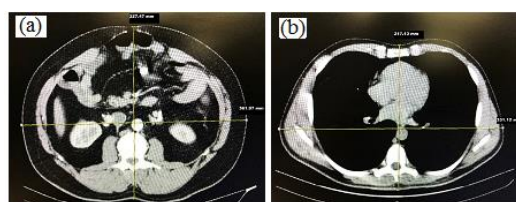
Example of AP and lateral dimensions measurement in abdomen-pelvis (a) and chest (b) CT scans
